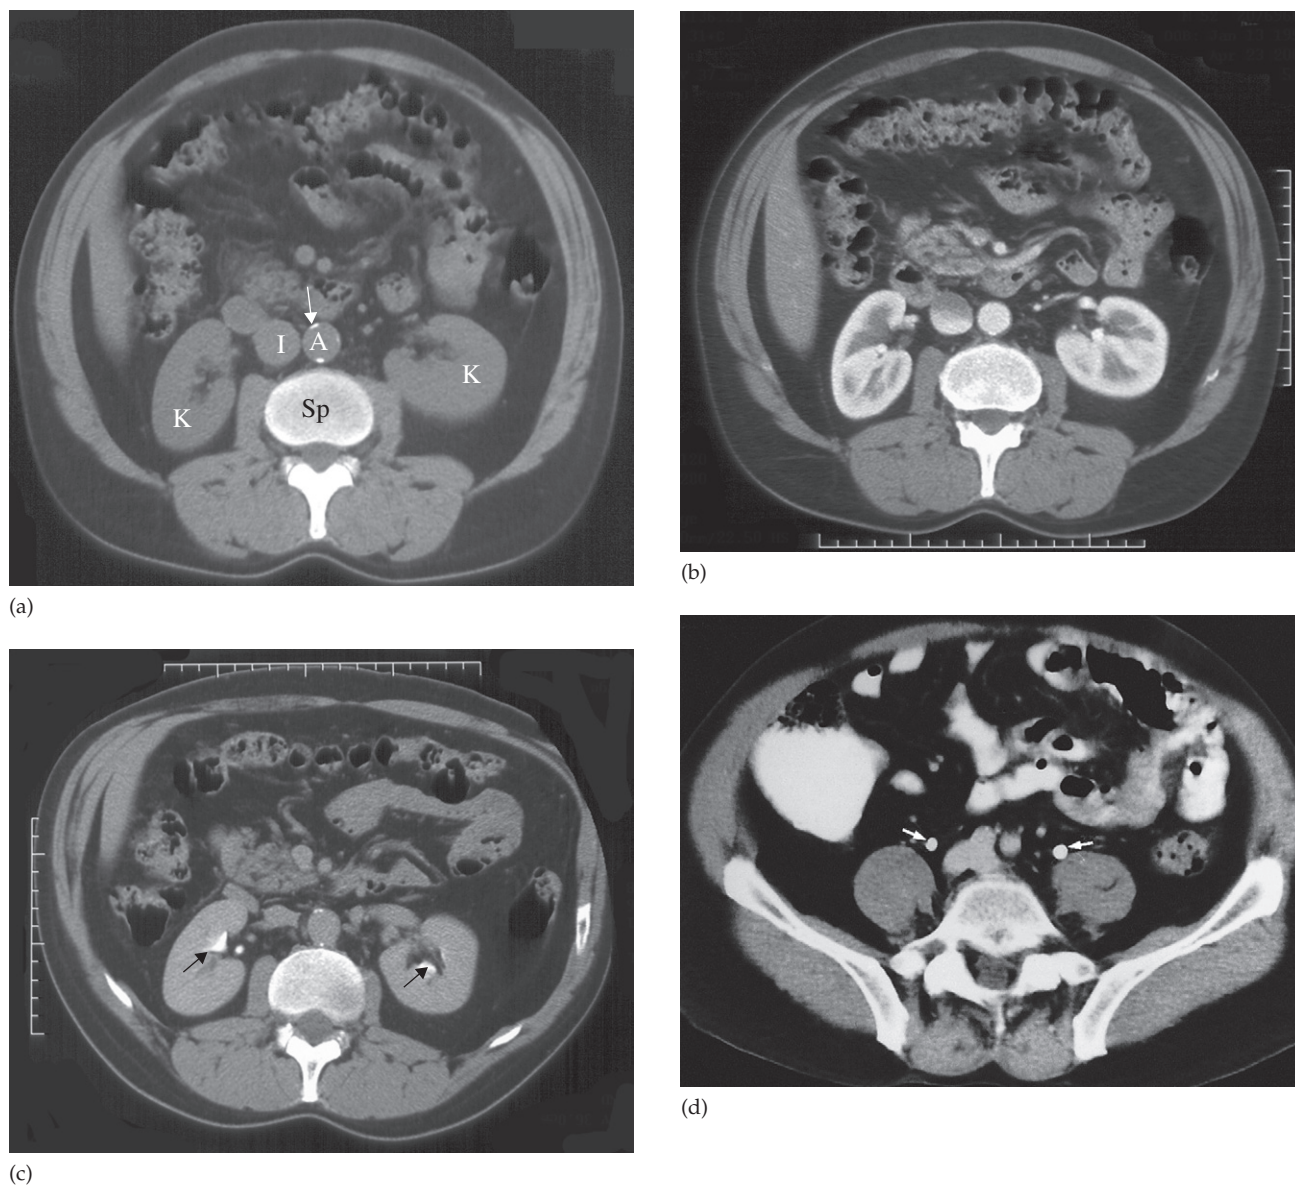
Normal CT of kidneys and bladder, with (a–c) showing the same level through the renal hilum. (a) Before the intravenous contrast has been given. Note the calcification in the wall of the aorta (arrow). A, aorta; I, inferior vena cava; K, kidney; Sp, spine. (b) Forty seconds after intravenous contrast infusion, demonstrating the corticomedullary phase, with marked enhancement of the renal cortex. (c) Ten minutes following the contrast infusion, demonstrating homogeneous opacification of the parenchyma and dense opacification of the pelvicaliceal system (arrows). (d) Section through the pelvis showing the ureters (arrows) ten minutes after contrast has been given.
